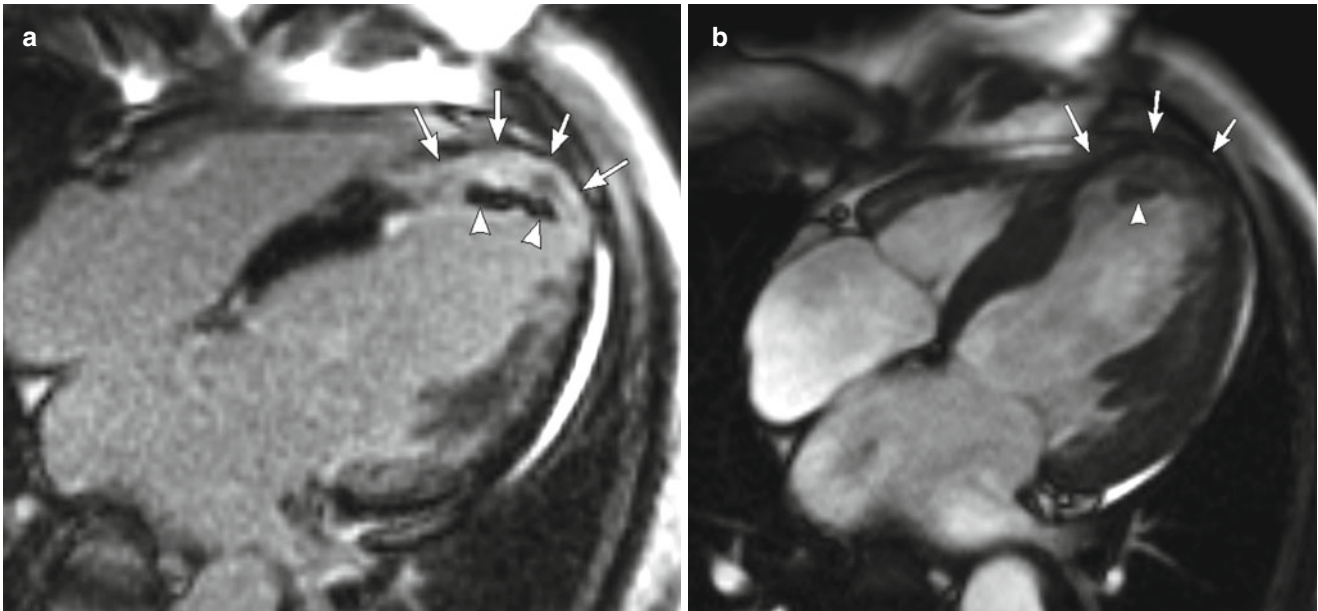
MRI of a patient with myocardial thinning and thrombus. (a) DE-MRI with 4-chamber view shows wall thinning (*arrows*) with hyperenhancement (*arrows*) and mural thrombus (*arrowheads*). (b) Cine MRI with 4-chamber view shows wall thinning (*arrows*) and thrombus (*arrowhead*)
